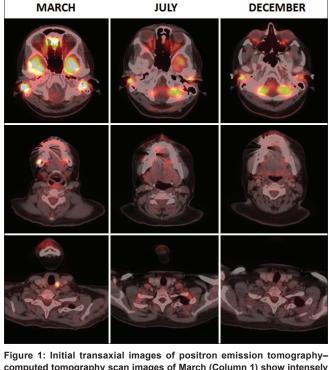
Initial transaxial images of positron emission tomographycomputed tomography scan images of March (Column 1) show intensely fluorodeoxyglucose avid lesions in bilateral external auditory canal, fluorodeoxyglucose avid osteolytic lesion in mandible, fluorodeoxyglucose avid hypodense nodule in left lobe of thyroid. Latter positron emission tomography-computed tomography images of July and December (Column 2 & 3) show complete response in mandible and thyroid lesion and moderate response was seen in bilateral external auditory canal lesions
